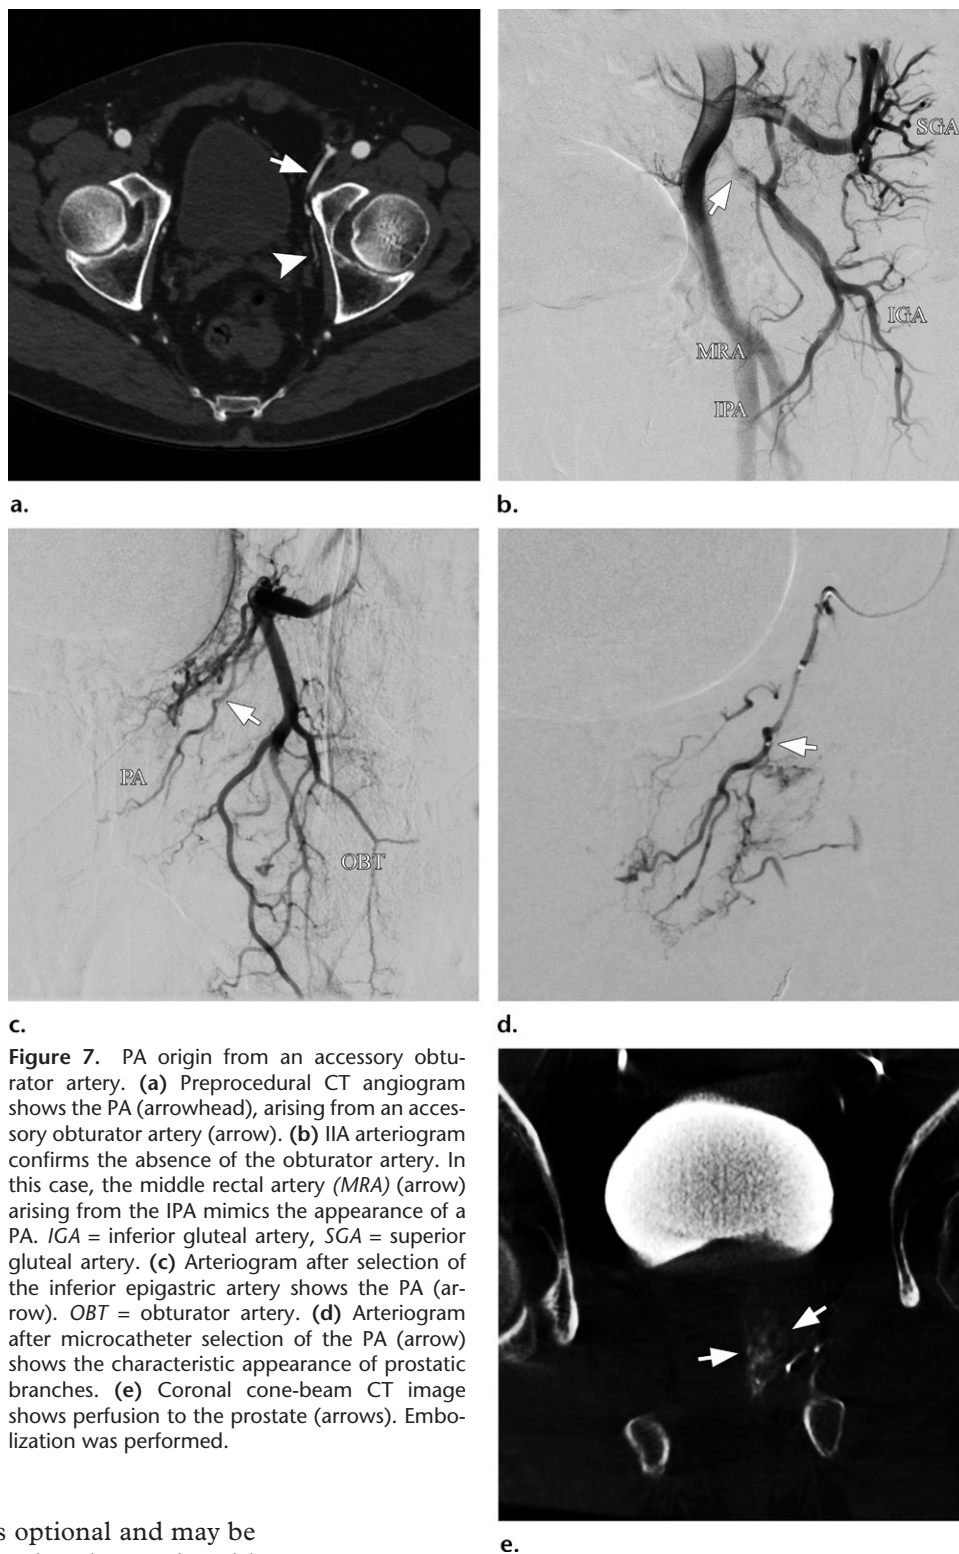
PA origin from an accessory obturator artery. (a) Preprocedural CT angiogram shows the PA (arrowhead), arising from an accessory obturator artery (arrow). (b) IIA arteriogram confirms the absence of the obturator artery. In this case, the middle rectal artery (MRA) (arrow) arising from the IPA mimics the appearance of a PA. IGA = inferior gluteal artery, SGA = superior gluteal artery. (c) Arteriogram after selection of the inferior epigastric artery shows the PA (arrow). OBT = obturator artery. (d) Arteriogram after microcatheter selection of the PA (arrow) shows the characteristic appearance of prostatic branches. (e) Coronal cone-beam CT image shows perfusion to the prostate (arrows). Embolization was performed.
